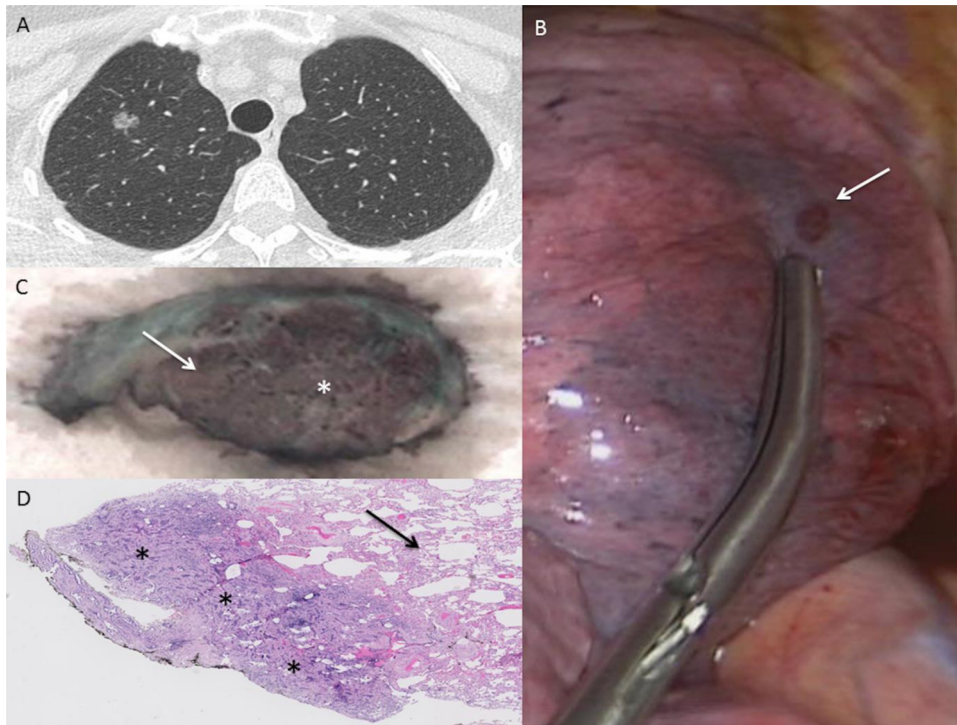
A. CT scan of the patient showing a non-solid nodule of 12 mm in diameter within the right upper lobe. B. Methylene blue visualized at the pleural surface. The arrow shows the hematoma secondary to TBLC. C. Macroscopic view of the segmentectomy guided by the dye marking. The arrow shows the methylene blue within the lung parenchyma. The star shows the tumor. D. The pathological analysis of the segmentectomy revealed an adenocarcinoma (stars) with adjacent normal lung parenchyma (arrow).
